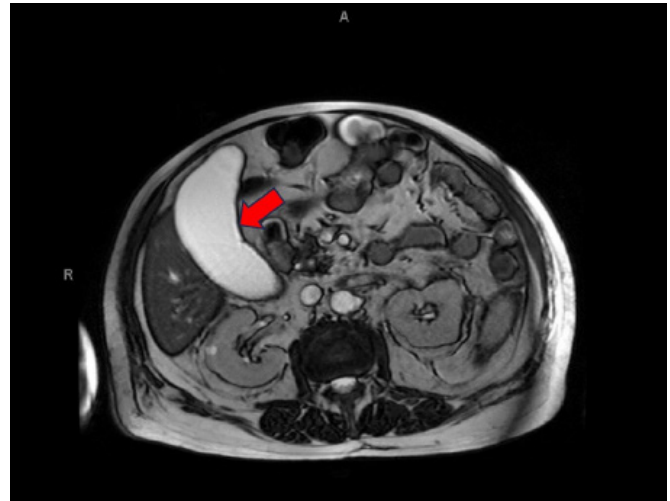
Initial CT Findings of Gallbladder Hydrops. Published with Permission
